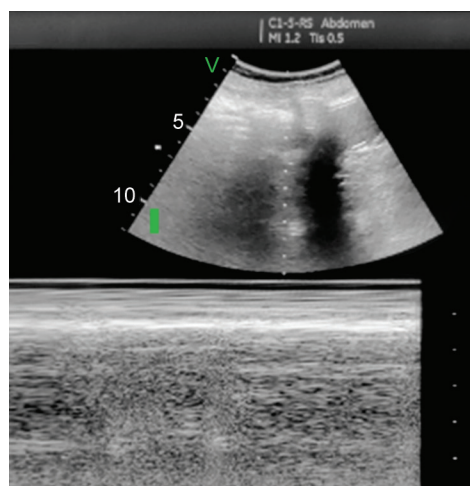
Right diaphragm paralysis: There's no movement at all, showing up as a flat tracing on the ultrasound
